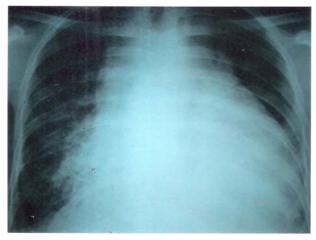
Chest radiograph (postero-anterior view) showing mediastinal widening and cardiomegaly.
